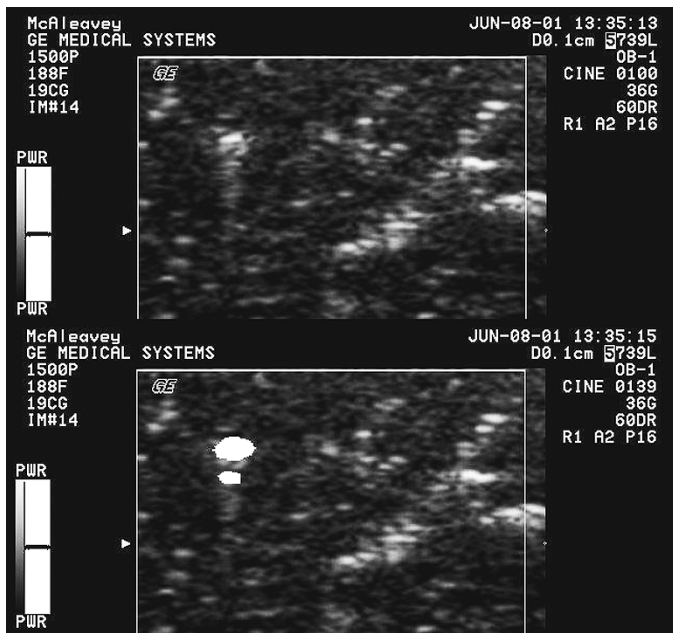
Power Doppler images of a steel seed in liver with no field (top) and a 60-Hz magnetic field (bottom) applied.
